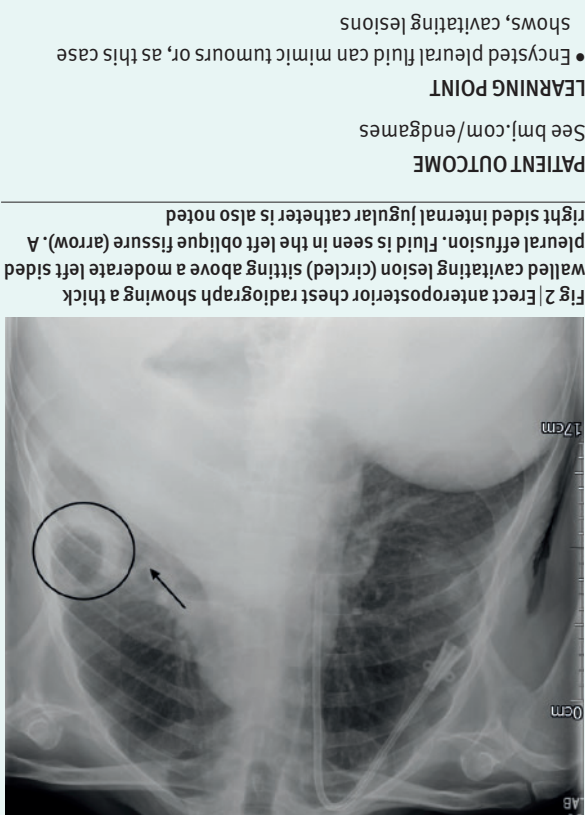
Erect anteroposterior chest radiograph showing a thick walled cavitating lesion (circled) sitting above a moderate left sided pleural effusion. Fluid is seen in the left oblique fissure (arrow). A right sided internal jugular catheter is also noted
